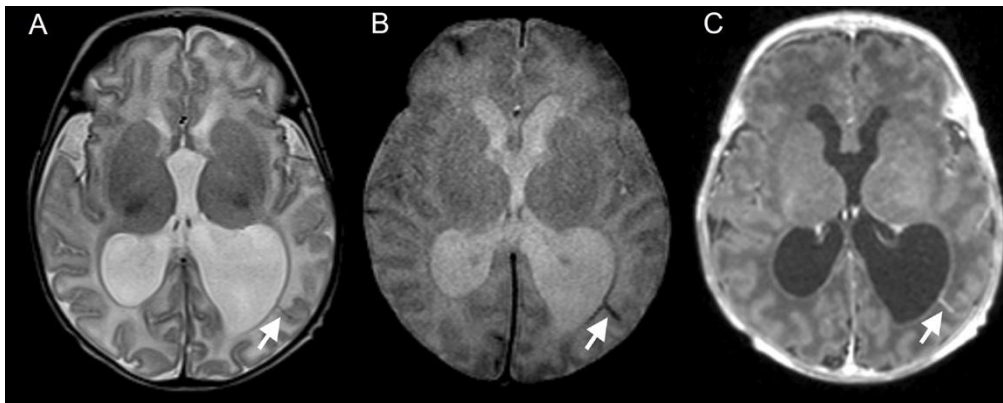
Post-natal brain MRI of the same child presented in Fig. 1.3.1 at 4 weeks of age (corresponding to 39 weeks' corrected age). Axial T2-weighted (A), gradient echo (B) and axial T1 contrast-enhanced (C) images showing the linear structure with vascular flow-void and enhancement in the left parietal region compatible with a subependymal developmental venous anomaly with cortical drainage (*white arrows*).
